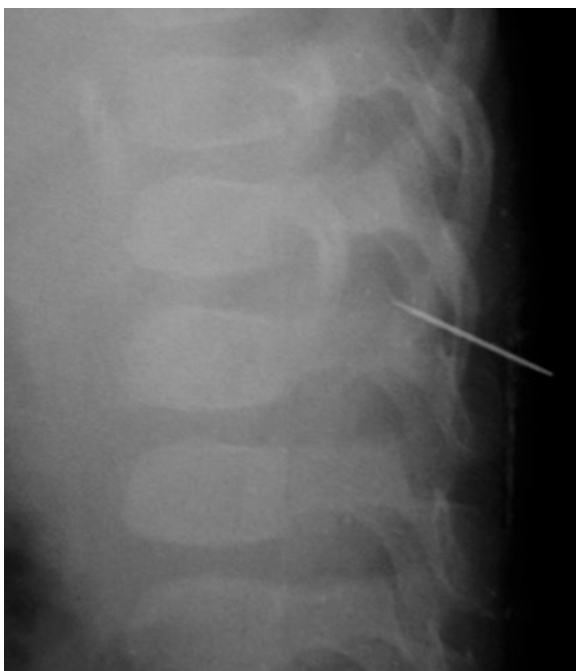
Lateral plain radiograph of the thoracolumbar spine showed a metallic foreign object.
